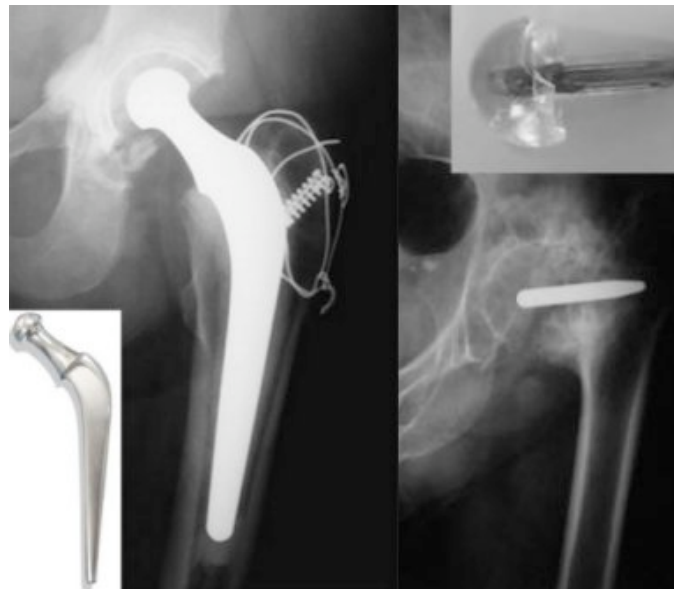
Radiographs and photographs of Charnley (left) and Judet (right) prostheses.
